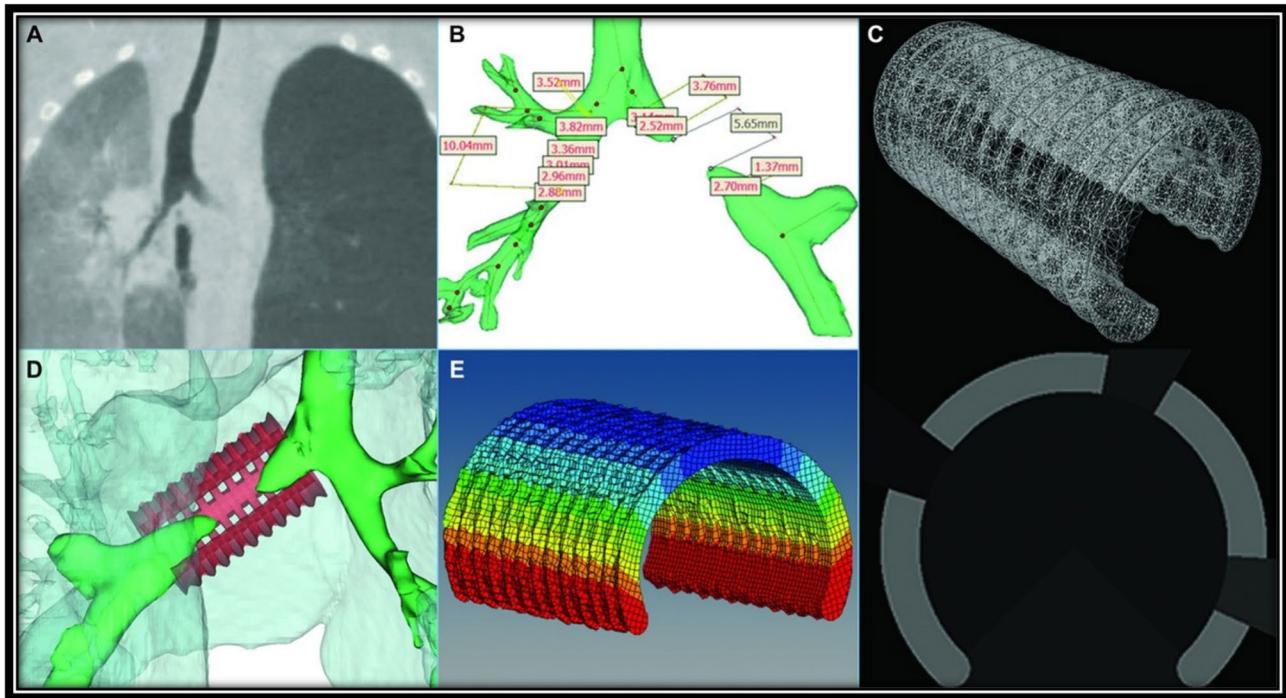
The design process of the tracheobronchial splint (TBS). A Imaging of the airway using computed tomography (CT) to describe the location and severity of the disease. B DICOM images from the CT scan are utilized to make a 3D model of the patient's airway within Mimics (Materialized), where measurements are accomplished to produce design inputs of the device. C Design inputs are directed into a proprietary MATLAB (MathWorks) code which produces a series of 2D. TIFF images (image represented at the top). These
